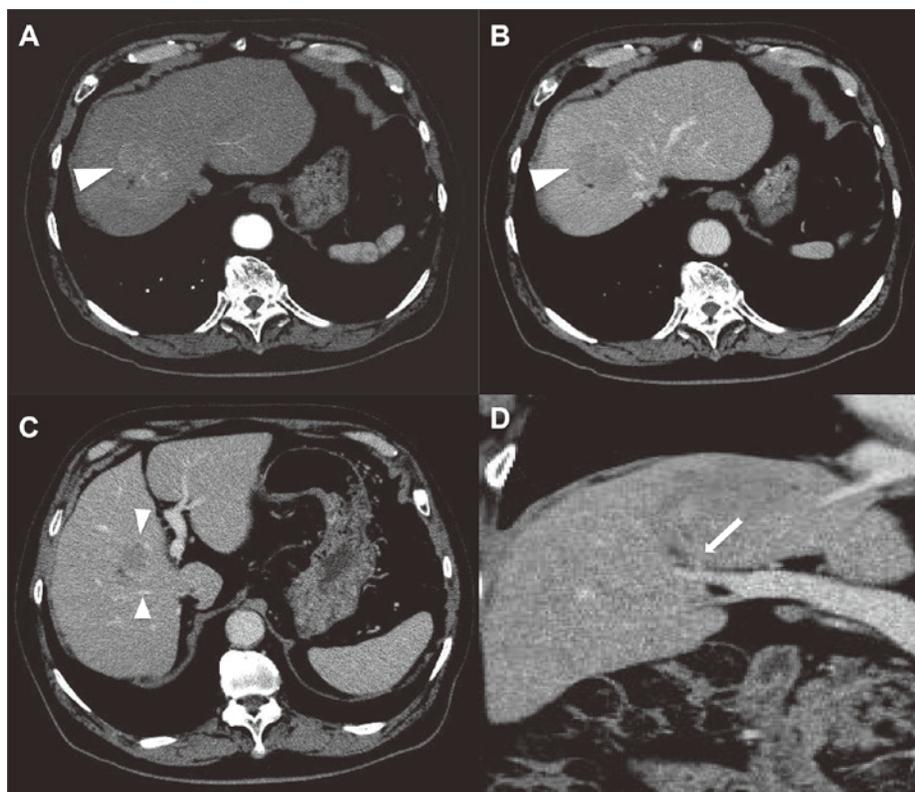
Computed tomography of the abdomen showed an 8-cm hepatocellular carcinoma (A, B : arrowheads) located in segment VIII close to both the right and middle hepatic veins (C : arrowheads) with a thrombus in the right branch of the portal vein (D : arrow).
